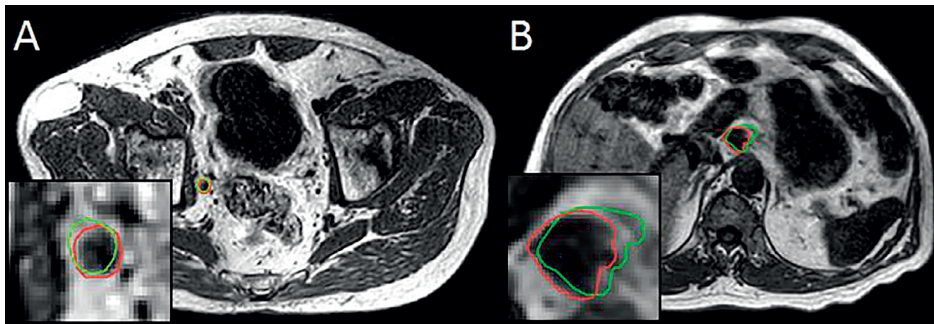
Example cases intra-fraction target motion of lymph node oligometastases in the pelvic (A) and para-aortic (B) region. Visible are the post-delivery MRIs with the online planning GTV (green) and the GTV as observed on the post-delivery MRI (red).
